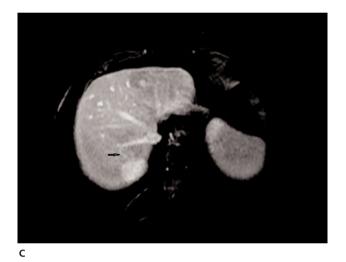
Blood flow is observed (A) in US, in the cystic lesion detected in the 7th segment of the liver, and in the tubular structure connecting right portal vein to the lesion (B) in Color Doppler US.
